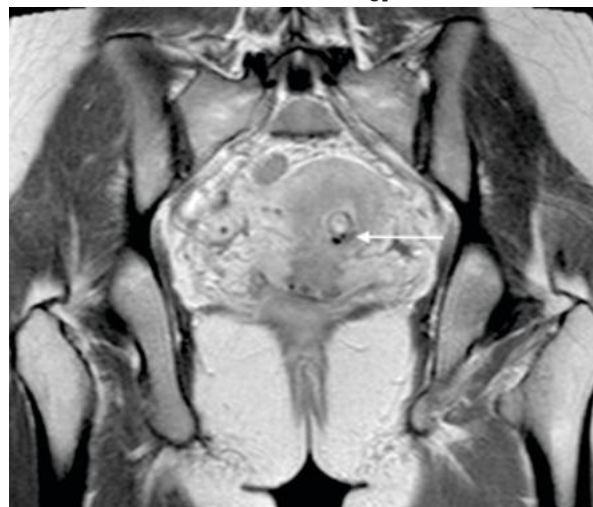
Coronal MRI Pelvis T1W Post Intravenous Gadolinium Administration Showing Serpiginous Low Signal Flow Voids in the Myometrium and a Uterine AVM.
